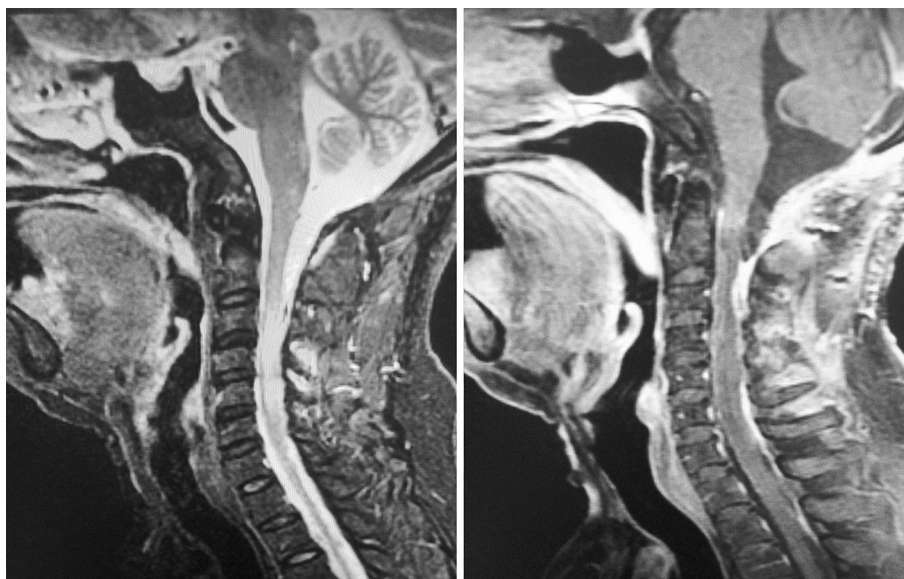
Postoperative imaging, day 1. Sagittal fast relaxation fast spin-echo T_2 (Upper left) and sagittal spin-echo T_1 post gadolinium (Upper right) demonstrating removal of the cyst with C4 tethering. Axial T_1 MR imaging with contrast at C1 (Bottom left) and at C2 (Bottom right) demonstrating removal of the cystic lesion removal posterior to the respective lamina
